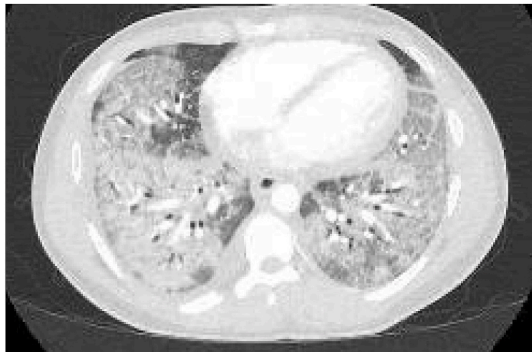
Axial sections of CT chest showing diffuse bilateral ground glass opacities in lungs.
